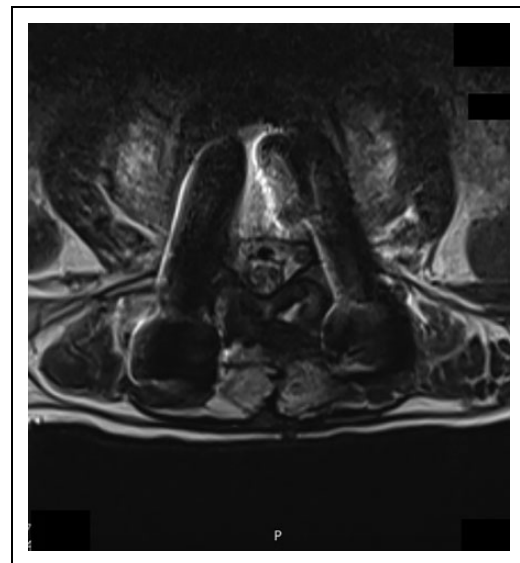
Axial magnetic resonance image of same patient at L4-L5 level.
